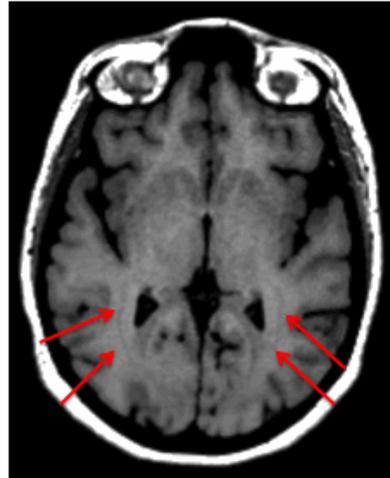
3 Tesla MRI, Axial T1weighted sequence without contrast. External sagittal stratum sample case. Thin, linear isointense to grey matter signal paralleling the posterior horns of the lateral ventricles mimicking band heterotopia. (Red arrows)
